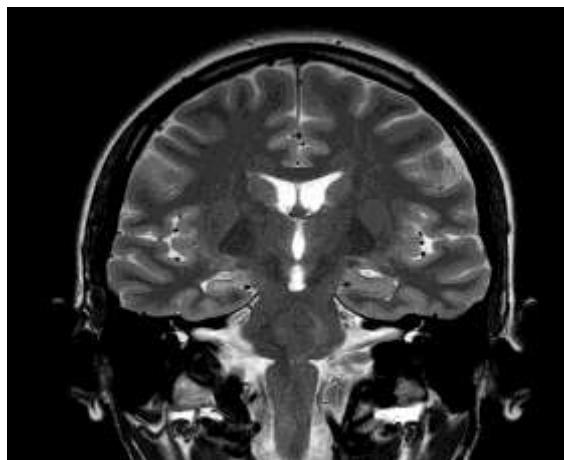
Coronal T2-weighted image showing left hippocampal sclerosis with associated dilatation of the ipsilateral temporal horn
